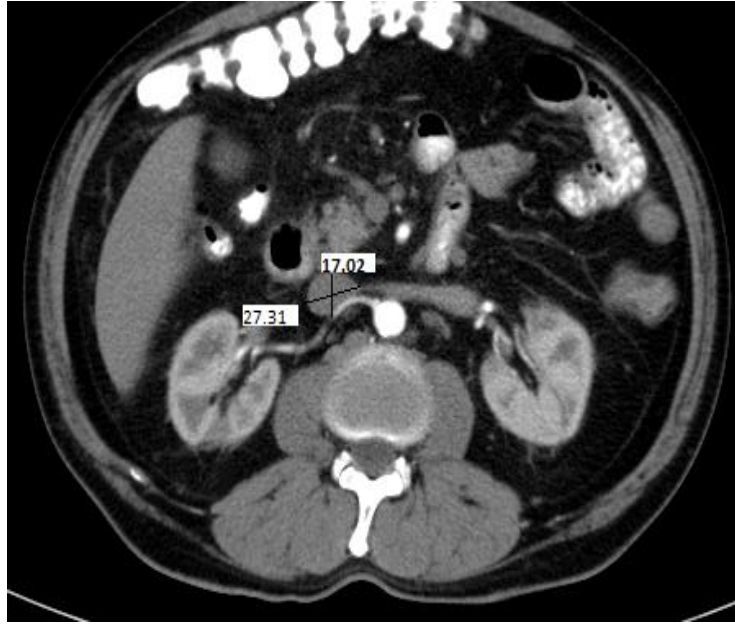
Axial CT Scan image showing aortic diameters measurements of 47 years old male at T12 level
